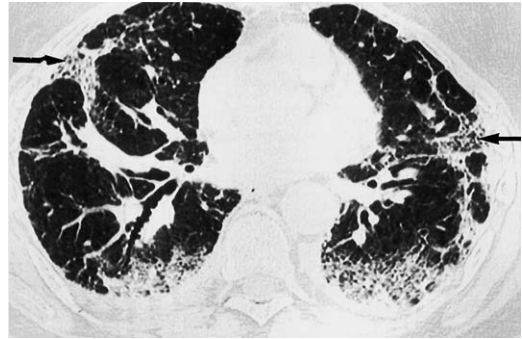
UIP in a 57-year-old woman taking bleomycin. HRCT image shows subpleural fibrosis with honeycombing (arrows) and traction bronchiectasis. This pattern was most prominent in the lung bases.
